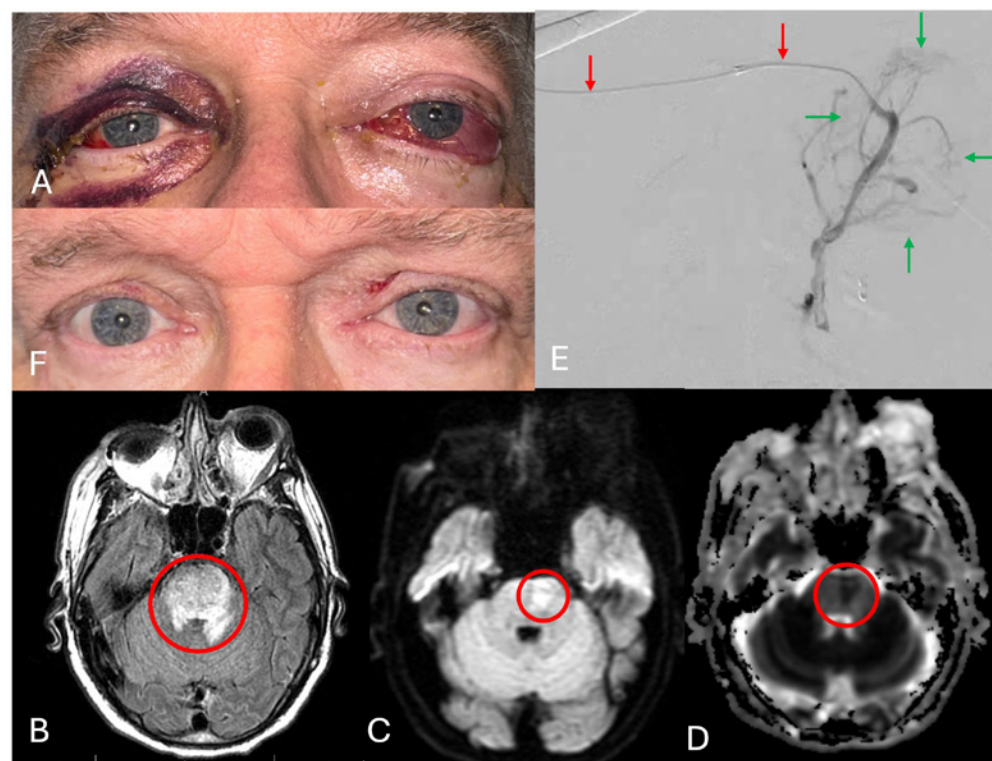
63 year old patient with PCVD and progressive dysarthria and right sided hemiparesis. A. Pre-operative clinical photos with left orbital congestion consistent with CCF. B. MRI FLAIR image demonstrating pontine edema (circle). C & D. DWI and ADC showing pontine stroke (circles). E. Cerebral arteriography demonstrates micro-catheter within SOV and cavernous sinus (red arrows). Note PCVD on contrast injection (green arrows).
